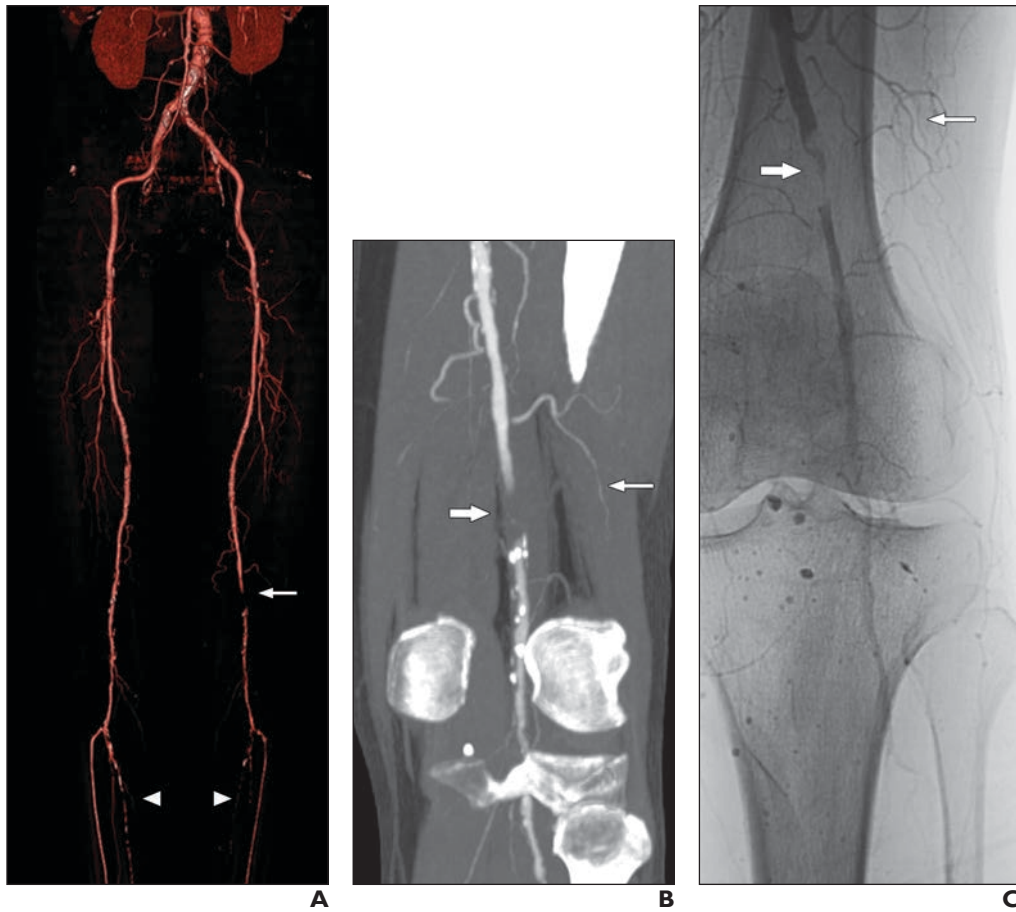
59-year-old man with peripheral arterial occlusive disease and intermittent claudication of left leg. Dual-source CT angiography was performed at 70 kV and 297 effective mAs/rotation (dose-length product, 427 mGy × cm).
